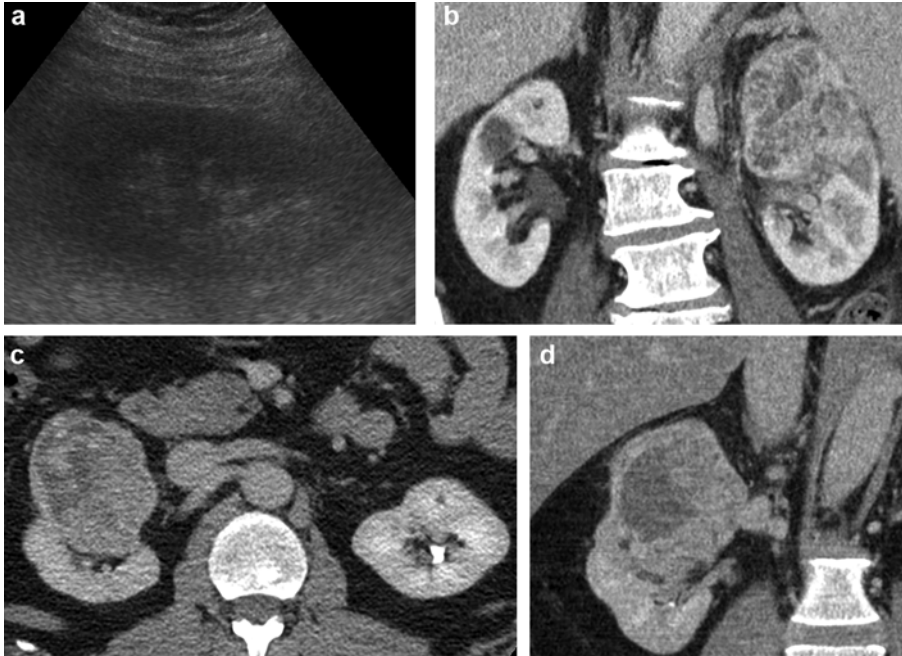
74M with 8 cm renal cell carcinoma of the left kidney. On US (a) the mass is isorefective to the renal parenchyma and closely approximates the renal contour, and was not identified. Coronal plane reformat of nephrographic-phase CT urography (b) demonstrates enhancing tumour in the upper pole.
